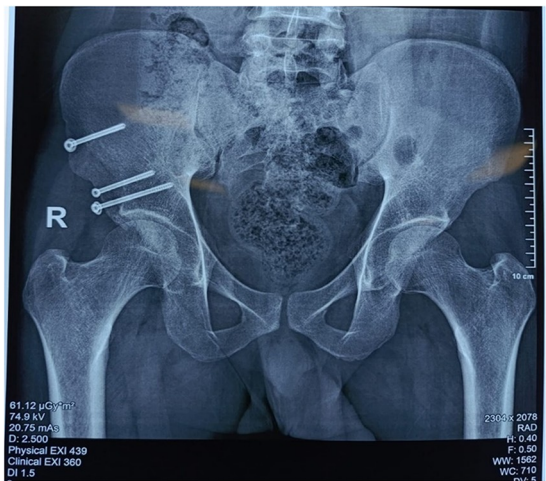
Follow up X-ray.
